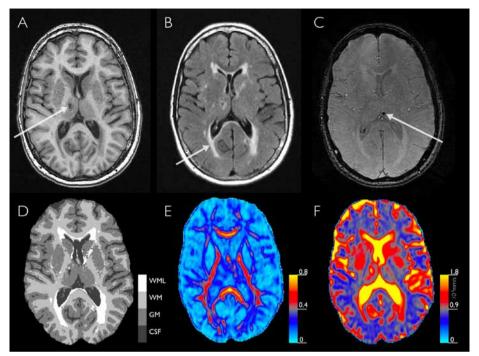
Structural and microstructural brain changes on MRI. Left on the image corresponds to right in the brain. A: Lacunar infarct (arrow) on T1-weighted image. B: White matter lesions (arrow) on FLAIR image. C: Cerebral microbleed (arrow) on T2*-weighted image. D: Tissue segmentation with each tissue type represented in a different grey value (darkest grey = cerebrospinal fluid, grey = grey matter, light grey = normal appearing white matter, white = white matter lesion). E: DTI-map of fractional anisotropy with larger values indicating larger anisotropy. F: DTI-map of mean diffusivity with larger values indicating larger diffusivity.
